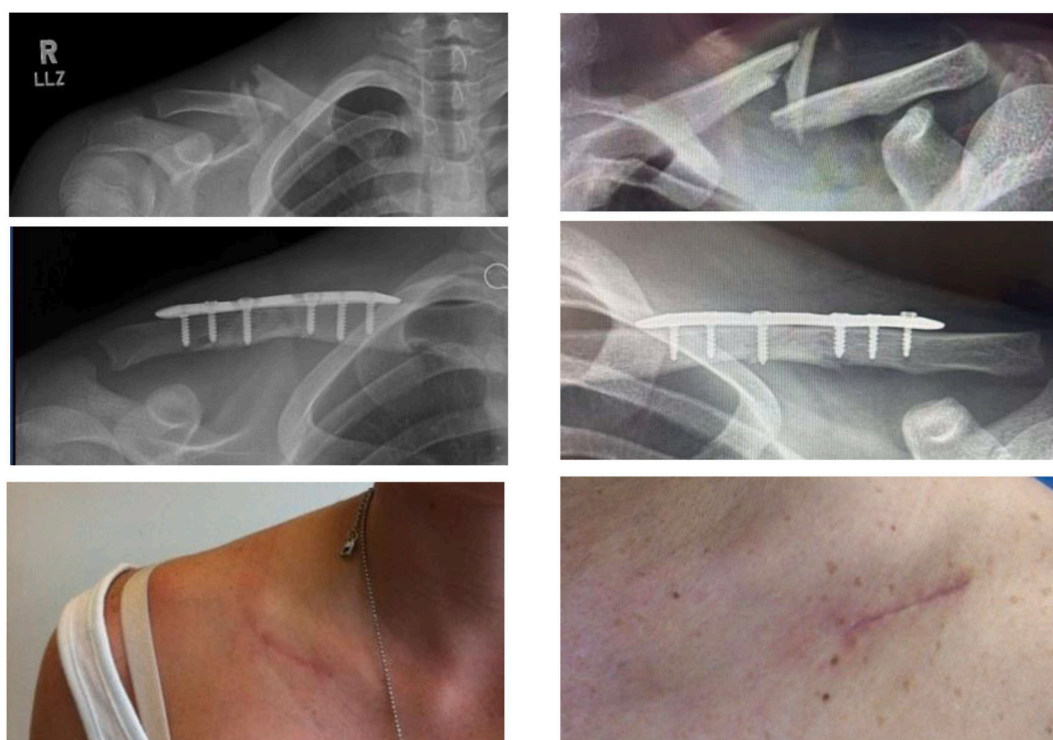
Case examples demonstrating preoperative X-rays (*top row*), postoperative X-rays (*center row*), and the healed scar at follow-up (*bottom row*).
